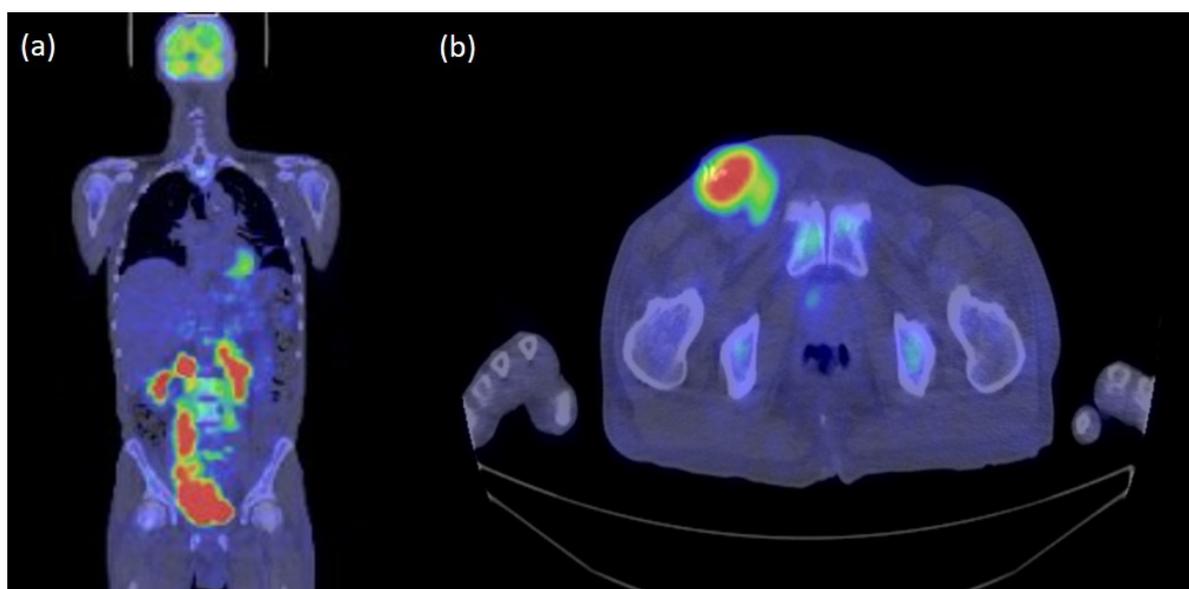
PET-CT images on admission. PET-CT on admission shows (a) multiple enlargement of subphrenic lymph nodes and (b) SUVmax 11.1 in the right inguinal lymph node.
